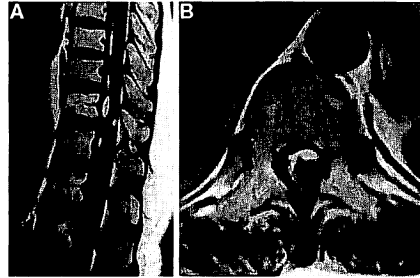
A, 56-year-old woman. Magnetic resonance images (T1-weighted spin-echo images at 1.0 T). The axial image is at level T11. A and B, on Day 7, subarachnoid hematoma extends from level T11–L2. Hematoma is mainly located ventrally and right laterally to the spinal cord.
